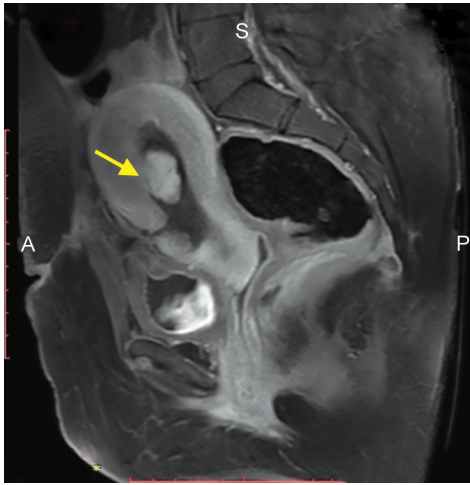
Magnetic resonance imaging of pelvis with contrast showing sagittal section of uterus with soft tissue mass adherent to anterior uterine wall suggestive of retained products of conception with coexistent arteriovenous malformation
